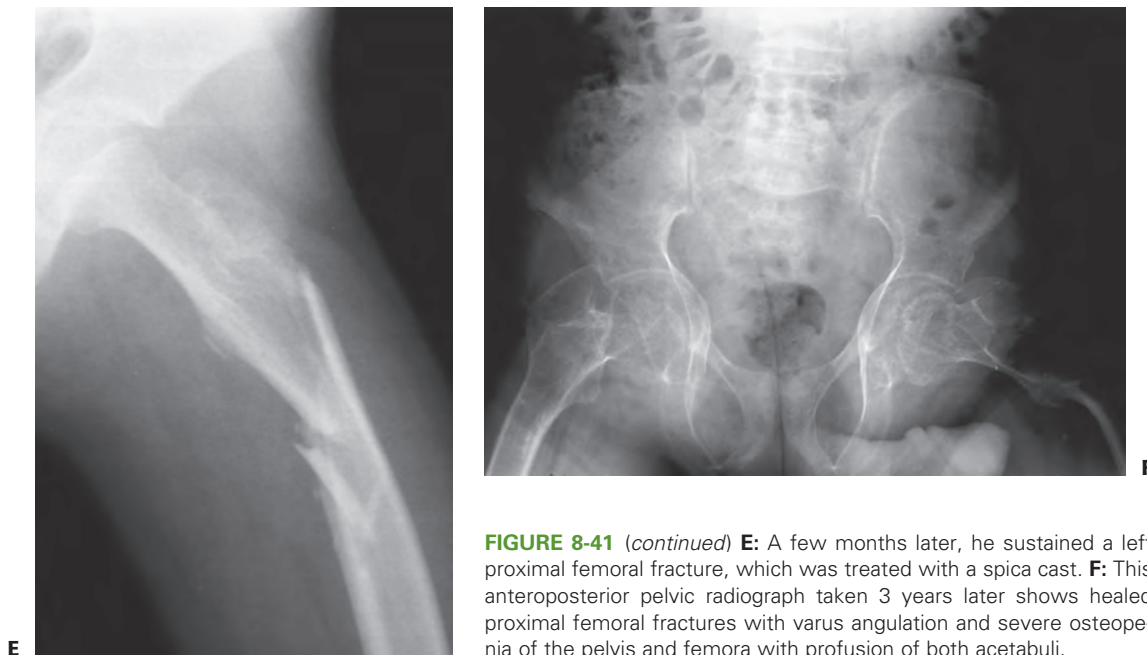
(continued) E: A few months later, he sustained a left proximal femoral fracture, which was treated with a spica cast. F: This anteroposterior pelvic radiograph taken 3 years later shows healed proximal femoral fractures with varus angulation and severe osteopenia of the pelvis and femora with profusion of both acetabuli.
